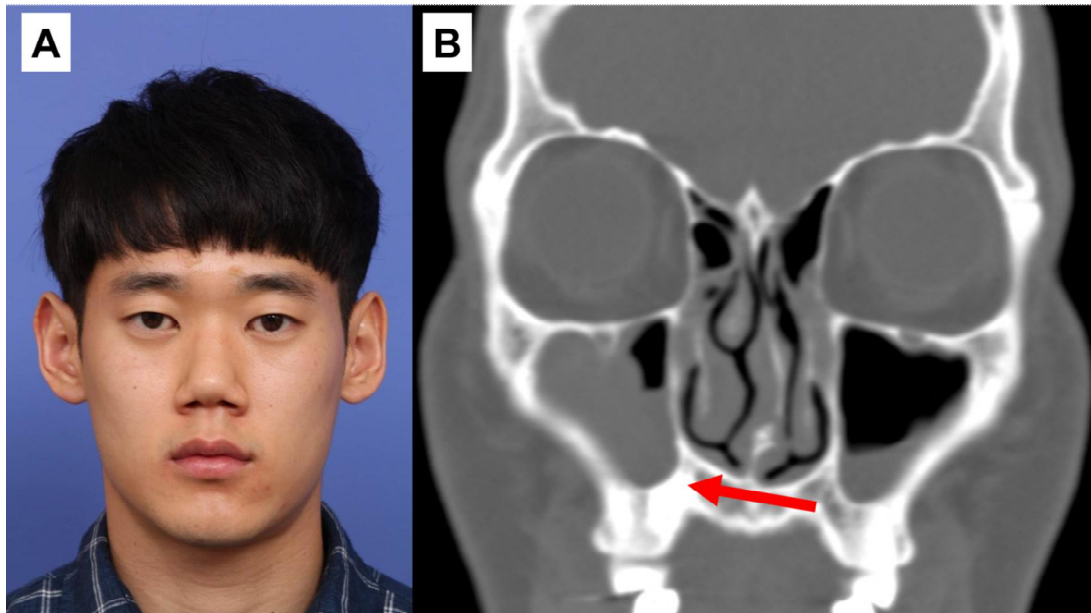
Correspondence of Nasal Floor Tilting Along with Nasofacial structures. Photograph of the frontal face and an OMU CT image of a 22-year old male patient, showing a higher location of the orbit and maxillary sinus in the right side, in addition to the smaller maxillary sinus on the right side, which is the side of a higher nasal floor. Additionally, the patient had a higher looking face on the right side. The lateral canthus margin and the lateral lip margin showed more superiorly on the right side, whereas there no level difference was observed in the alar base levels.
